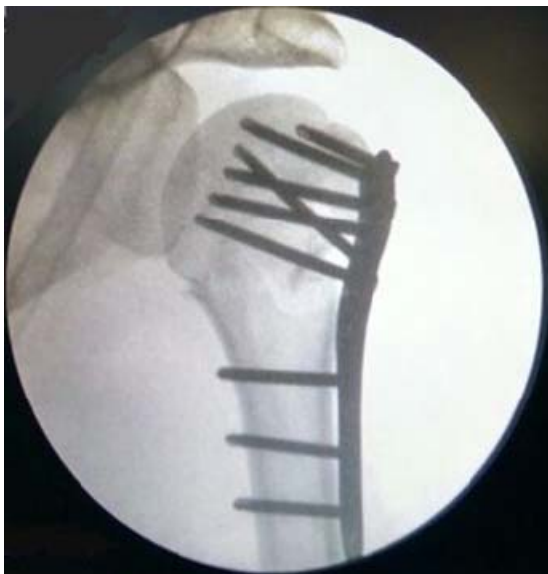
Post-op X-ray: Ideal positioning of the PHILOS plate
